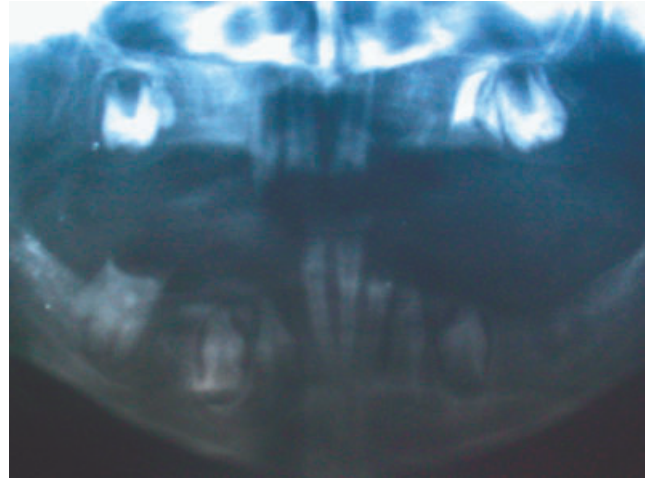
Orthopantomography
